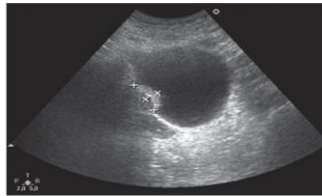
Ultrasonogram of bladder cancer.
